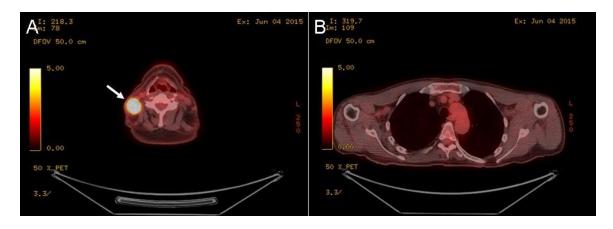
Panel A: PET/CT scan showing increased tracer uptake in the right neck (arrow). Panel B: No abnormal tracer uptake is seen within the chest.
